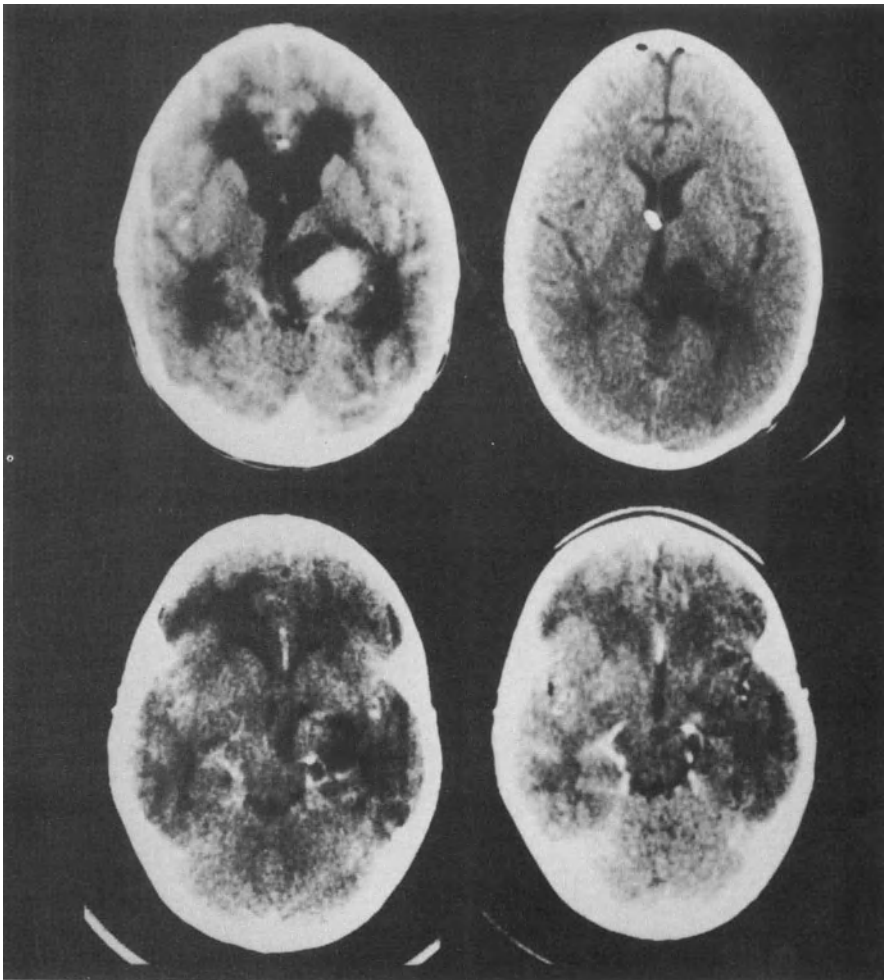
Preoperative and postoperative contrast-enhanced CT scan in a five-year-old girl with a pilocytic astrocytoma in the left thalamus, removed from the posterior approach (*top*). CT scan of an eight-year-old boy with a pilocytic astrocytoma resected by the anterior approach (*bottom*).
